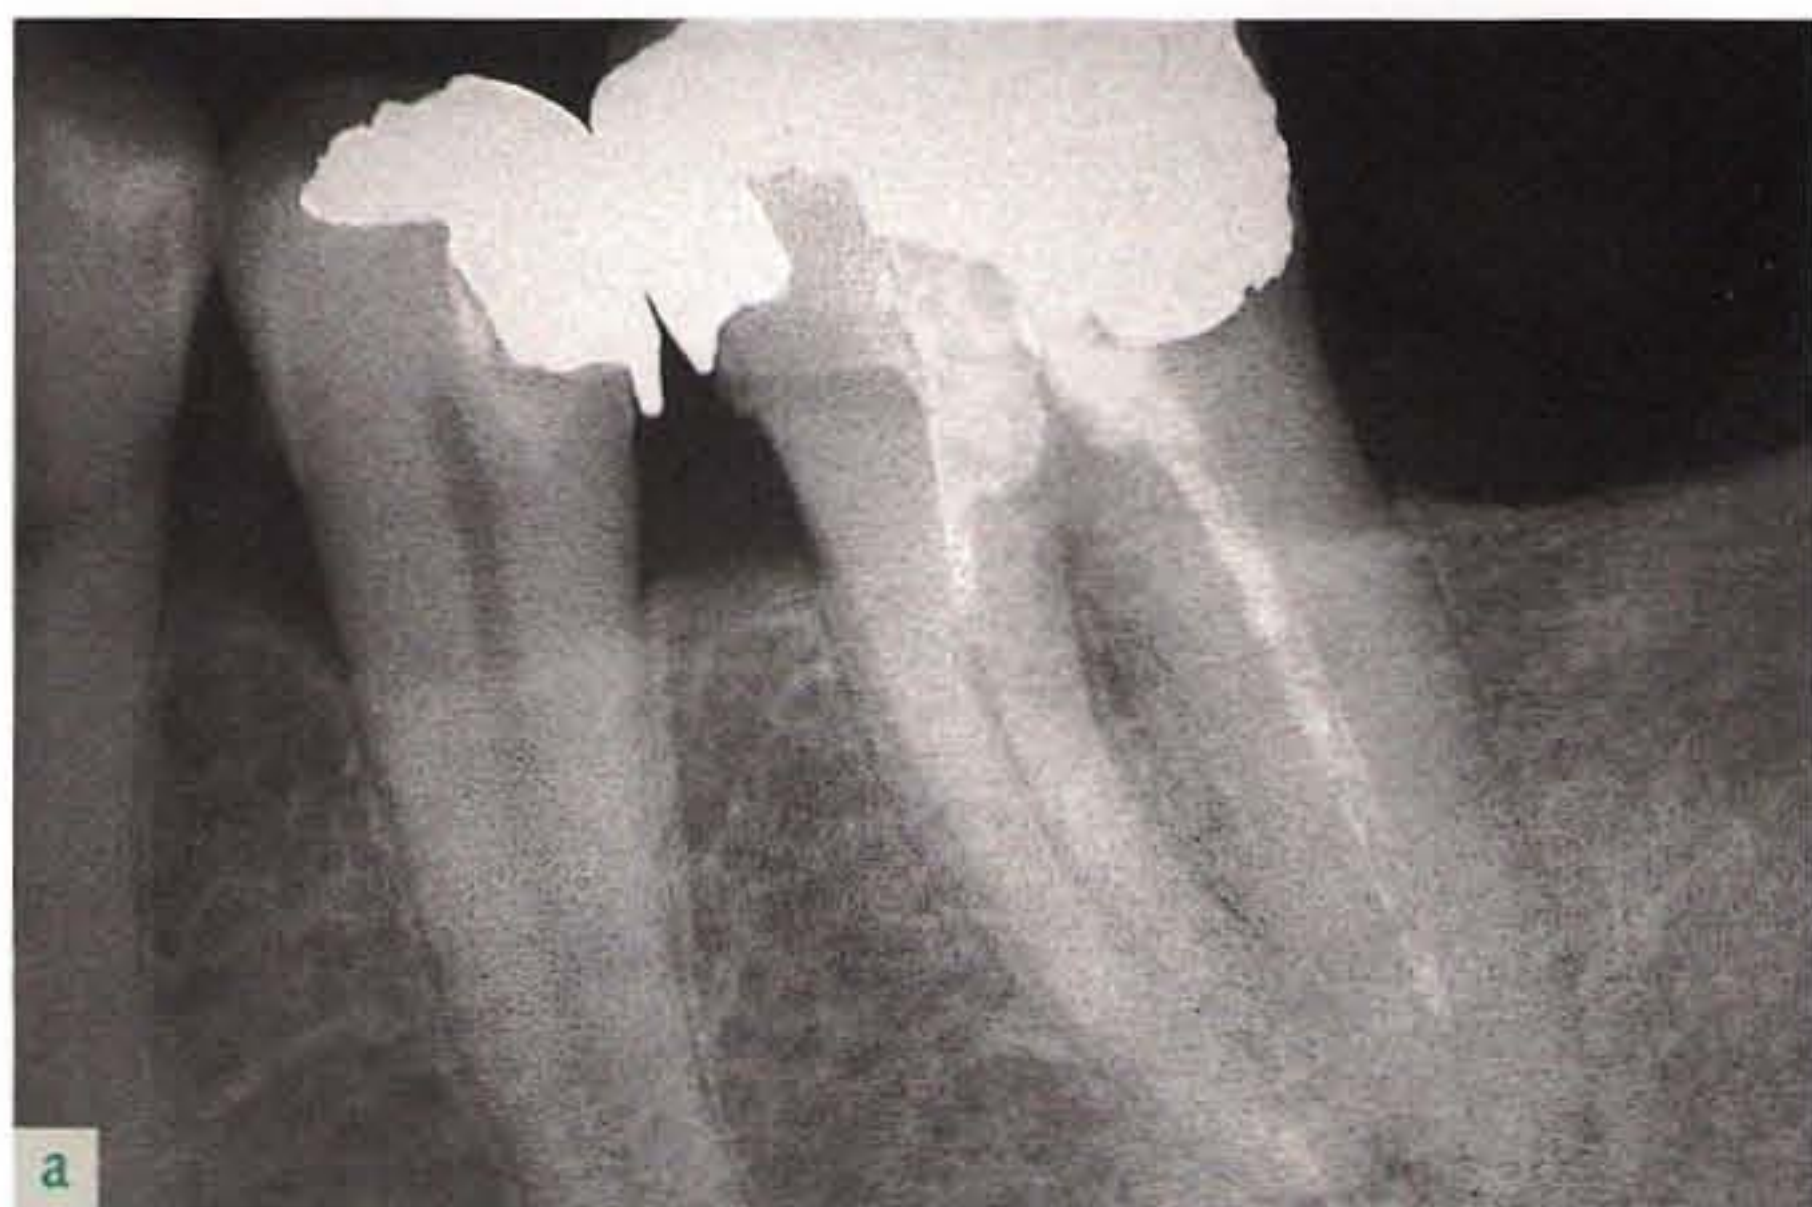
(*a*) Pretreatment radiograph of the mandibular left second molar, which is to have endodontic retreatment; (*b*) radiograph after endodontic retreatment and restoration with a gold-ceramic crown.
